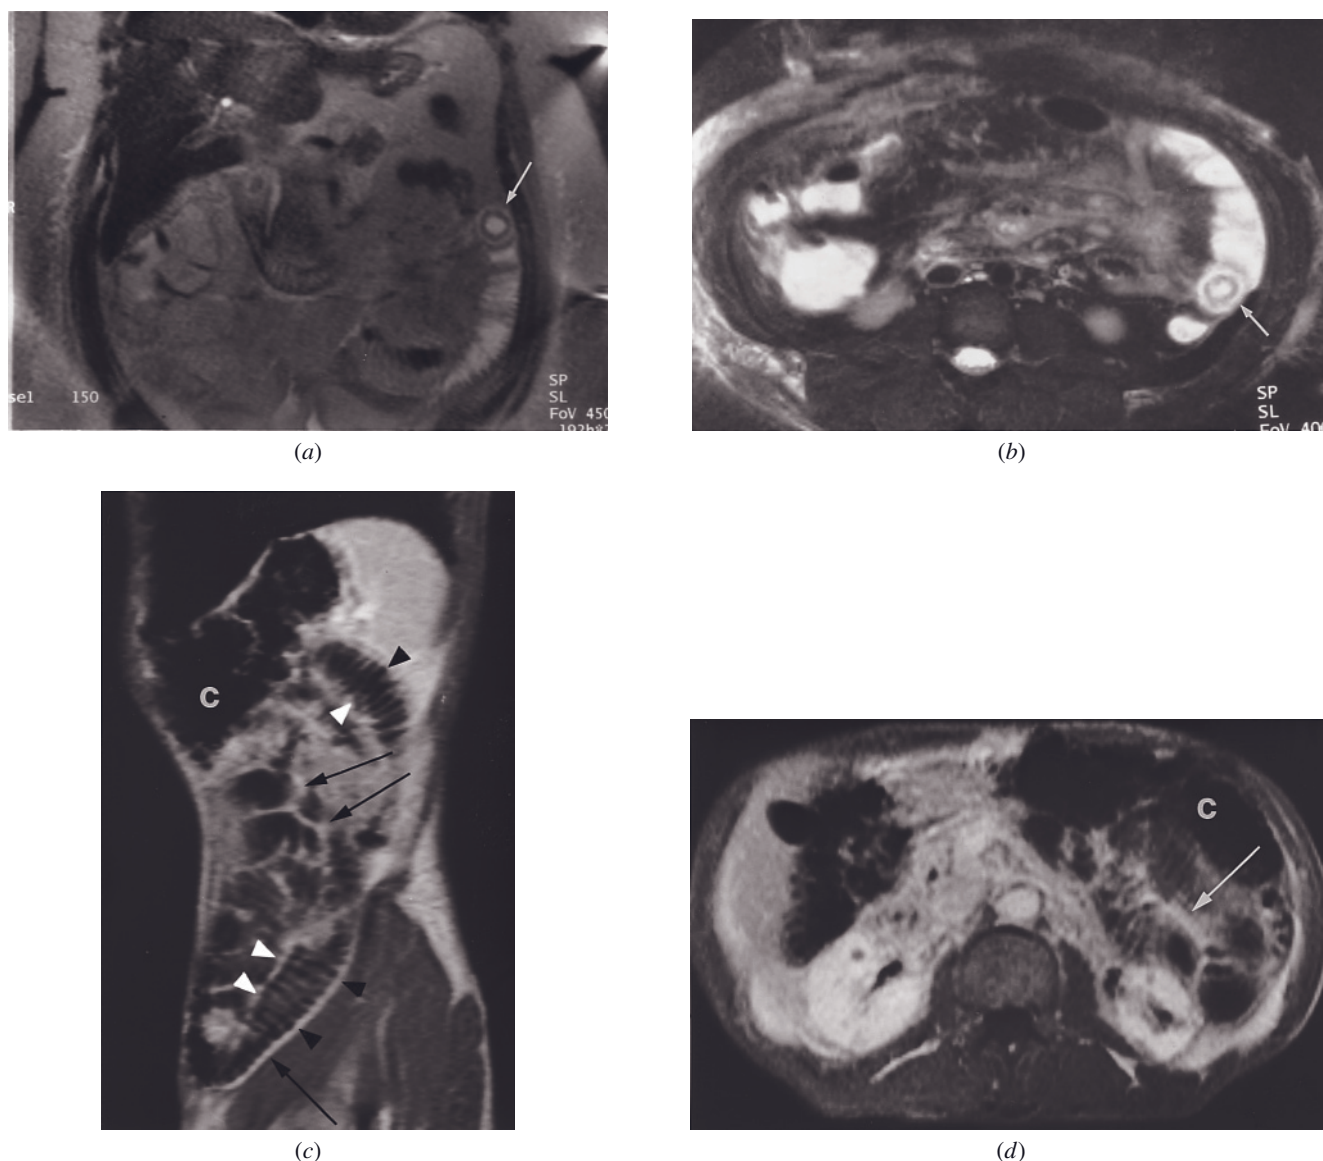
Small intestine inflammation secondary to pancreatitis. Coronal T2-weighted SS-ETSE (*a*) and T2-weighted fat-suppressed echo-train spin-echo (*b*) images demonstrate circumferential high signal intensity of the wall of the jejunum (arrow, *a*, *b*) secondary to edema caused by inflammatory changes induced by pancreatitis. The outer wall is high in signal intensity, whereas the inner wall is low in signal intensity, reflecting the extrinsic nature of the bowel inflammation. Sagittal (*c*) and transverse (*d*) interstitial-phase gadolinium-enhanced SGE images in a second patient demonstrate dilatation (arrowheads, *c*) of small bowel with increased wall enhancement (arrows, *c*, *d*). The transverse colon (*c*, *c*, *d*) shows a transition from normal caliber to narrowed, which is the transverse colon cutoff sign of pancreatitis.
